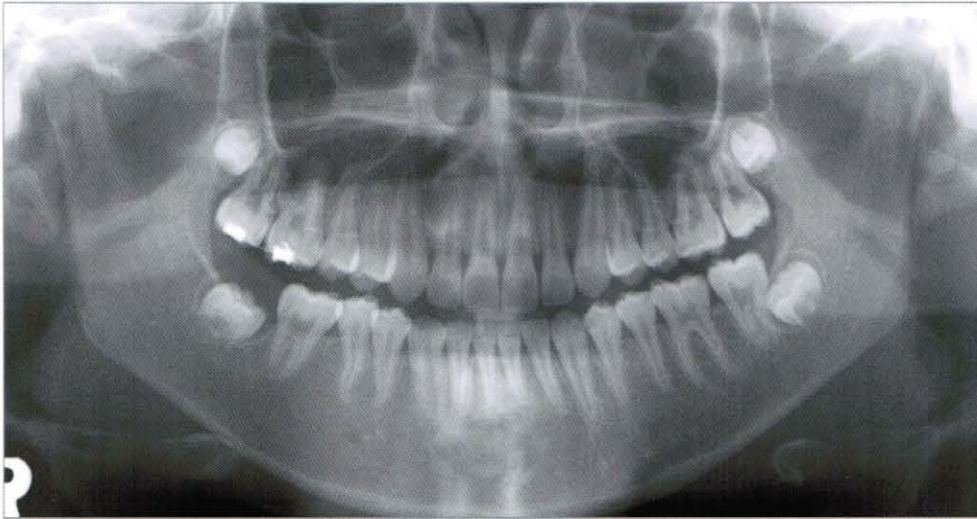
Panoramic radiograph at debonding (2006, 12,15)
